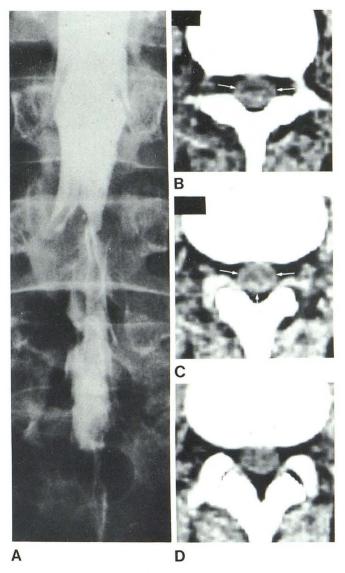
Postoperative arachnoiditis. A, Metrizamide myelogram about 1 year after diskectomies at L4-L5 and L5-S1 shows severe arachnoiditis from L3 to S1. B and C, CT at L3-L4 shows thickened sac wall (*arrows*). However, at L4-L5 (D), where myelogram also indicated definite arachnoiditis, wall of thecal sac did not appear thickened on CT.
